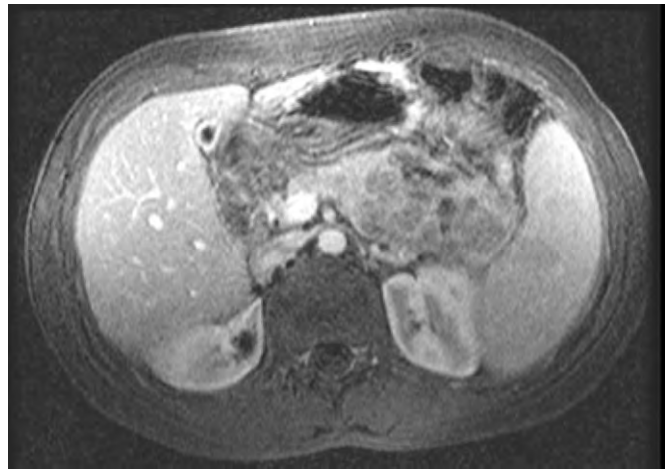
MRI showing neuroblastoma metastatic to the tail of the pancreas in a 16-year-old girl, appearing as a heterogeneous, multilobulated mass.
